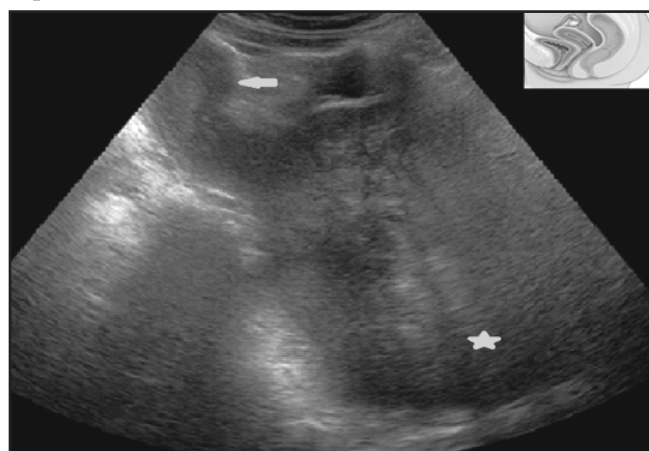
Grey scale ultrasound image showing heterogeneous, predominately hypoechoic mass in pelvis (asterisk). Uterus is seen separately( yellow arrow)
